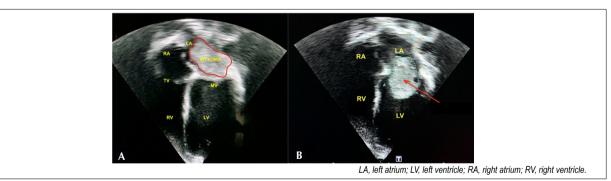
Left atrial myxoma. Transthoracic echocardiogram (apical 4-chamber view) demonstrating a large mobile mass (red arrow) in the left atrium with irregular contours (A) obstructing the LV inlet tract flow (B; Video clip 3).
